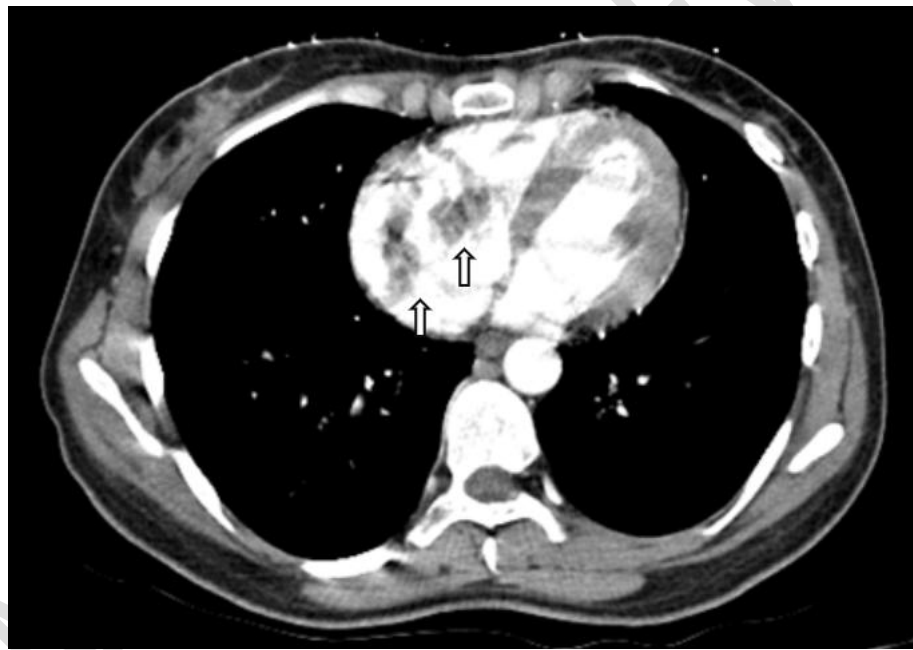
CT image showing intracardiac metastatic masses in dilated right cavities.
